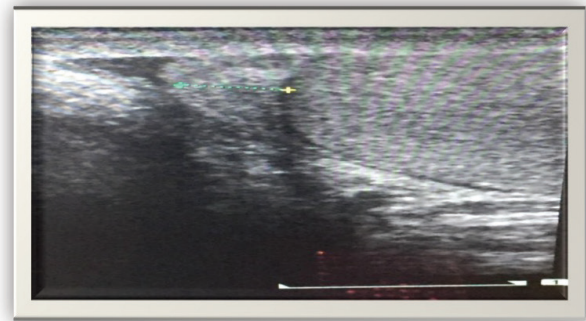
Ultrasound image of Normal epididymal head.
